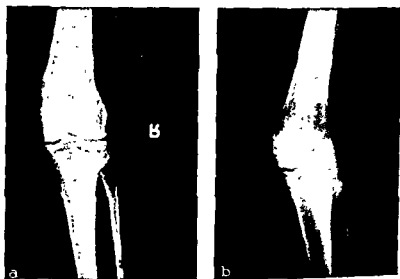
(Case 4) —*a* and *b*, Comparable roentgenograms six months after open reduction. The normal level of the plateau has been maintained. There is no pain or swelling on motion. When last examined six months postoperatively the patient exhibited normal extension and lacked 10 degrees of flexion as compared with the opposite knee, but it is believed that in the very near future she will establish normal range of flexion.
